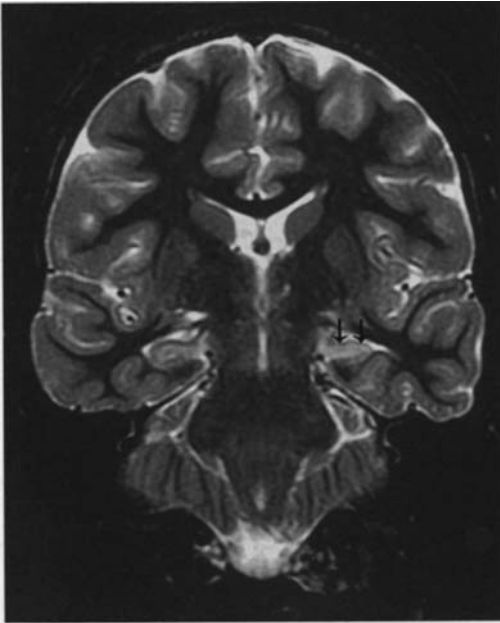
presents CT and MRI images of a child with epilepsy and postural plagiocephaly.
